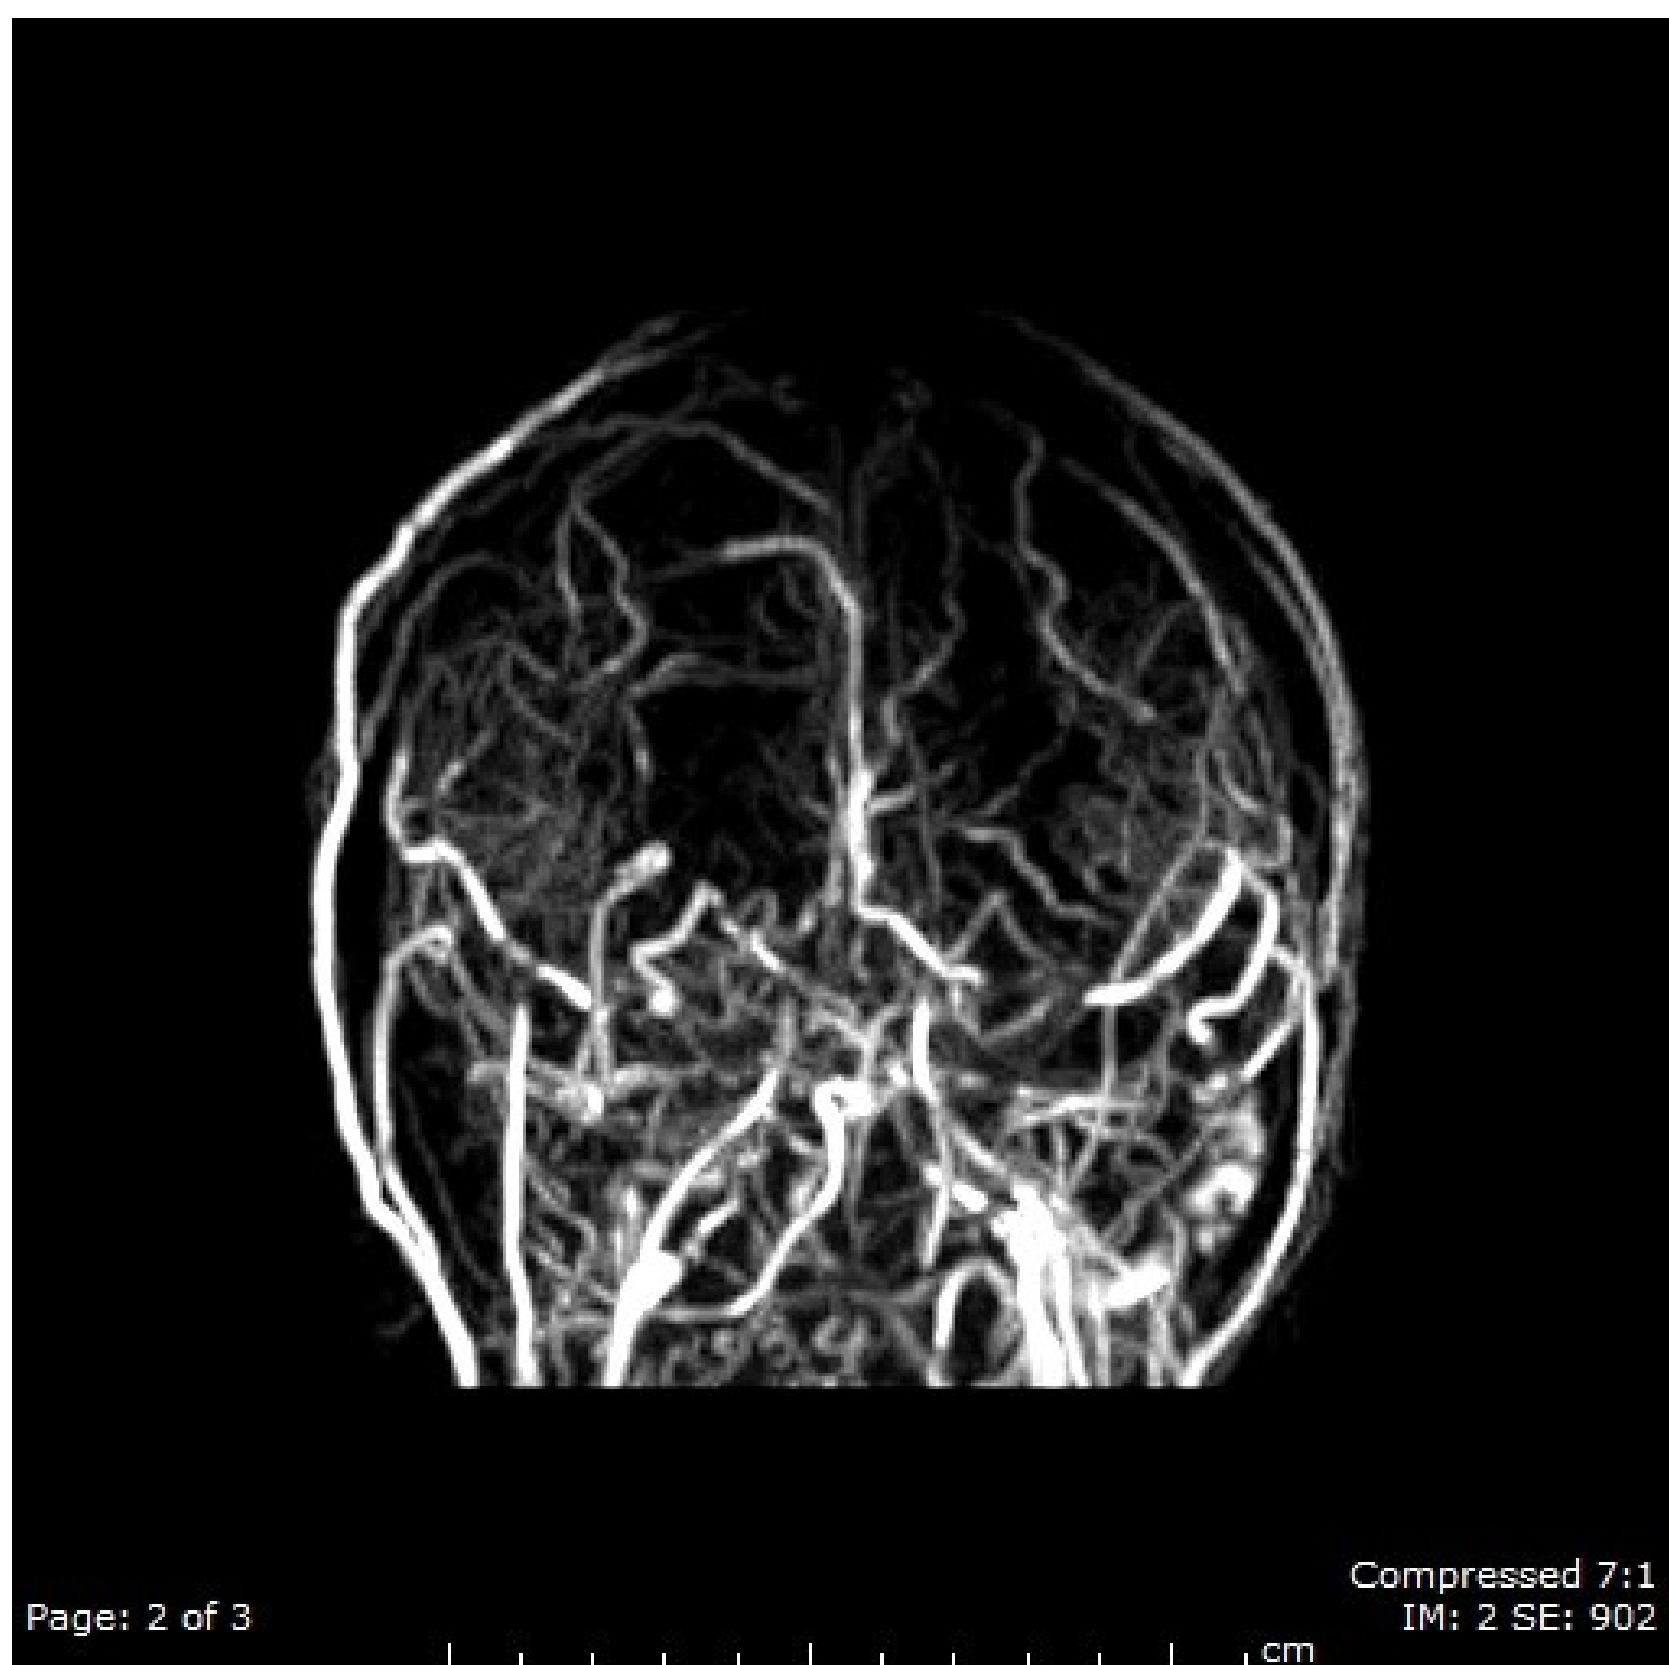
MRI Venography with 3D PCA sequences show multiple dural venous sinus thrombosis.
